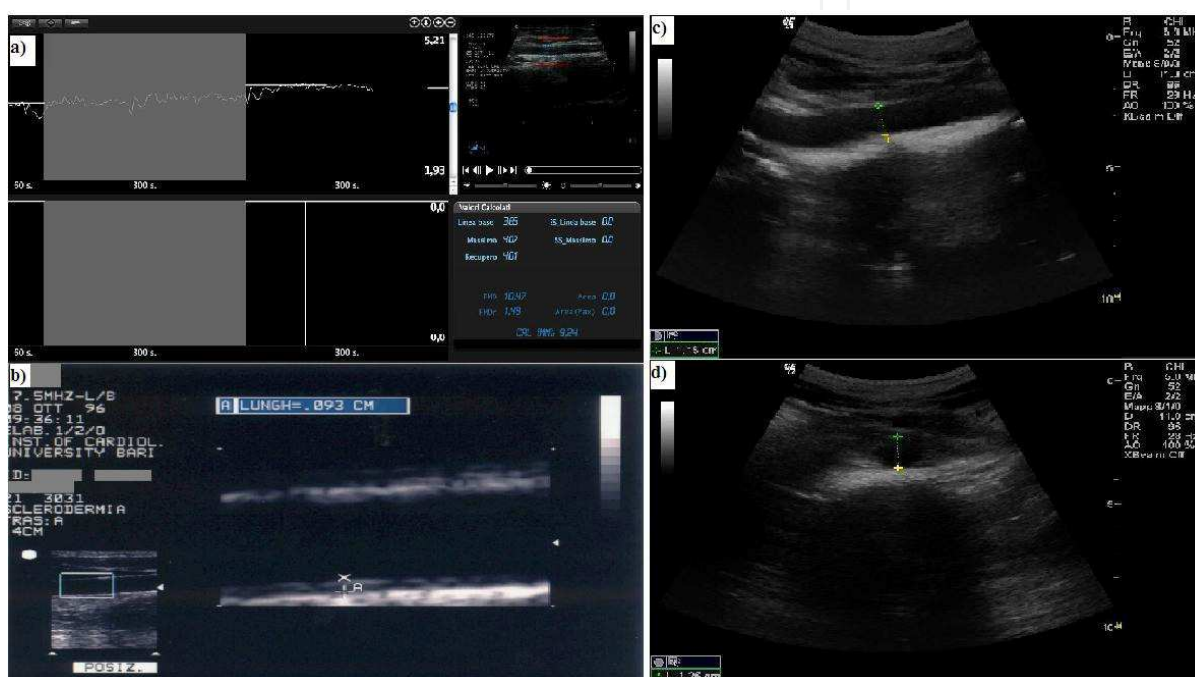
a) Flow-mediated vasodilation (FMD) technique image. b) Ultrasound evaluation of common carotid artery intima-media thickness. c) Antero-posterior abdominal aorta diameter in long axis views. d) Antero-posterior abdominal aorta diameter in short axis views
